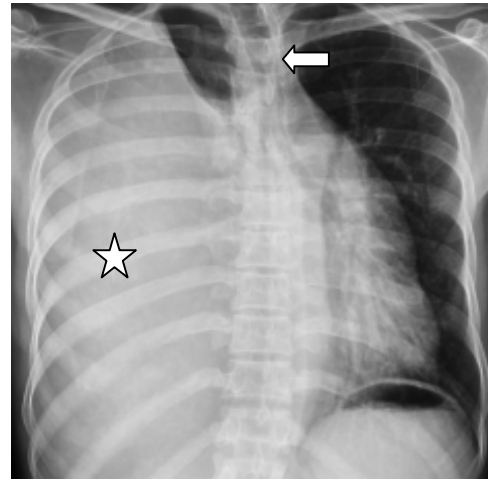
37-year old asymptomatic male diagnosed with mediastinal thymolipoma. Chest radiography frontal projection shows homogenous opacity (asterisk) involving the right hemi thorax with sparing of the apical segment of the right upper lobe. The trachea is mildly shifted to the left (left arrow)
